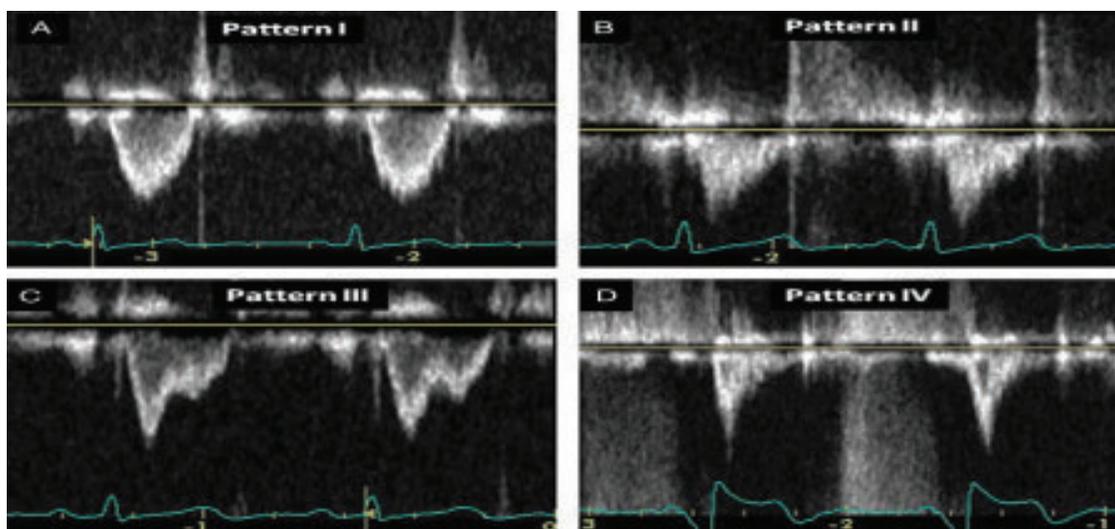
Right ventricular outflow tract Doppler spectral signals showed four dynamic patterns. (A) Pattern I was characterized by a parabola-like contour of the ejection flow velocity envelope. (B) Pattern II had a triangular contour as a result of an early systolic peak followed by a slow deceleration time. (C) Pattern III has mid-systolic notching and (D) pattern IV has significant reduction in signal volume resulting in a spiked appearance.
